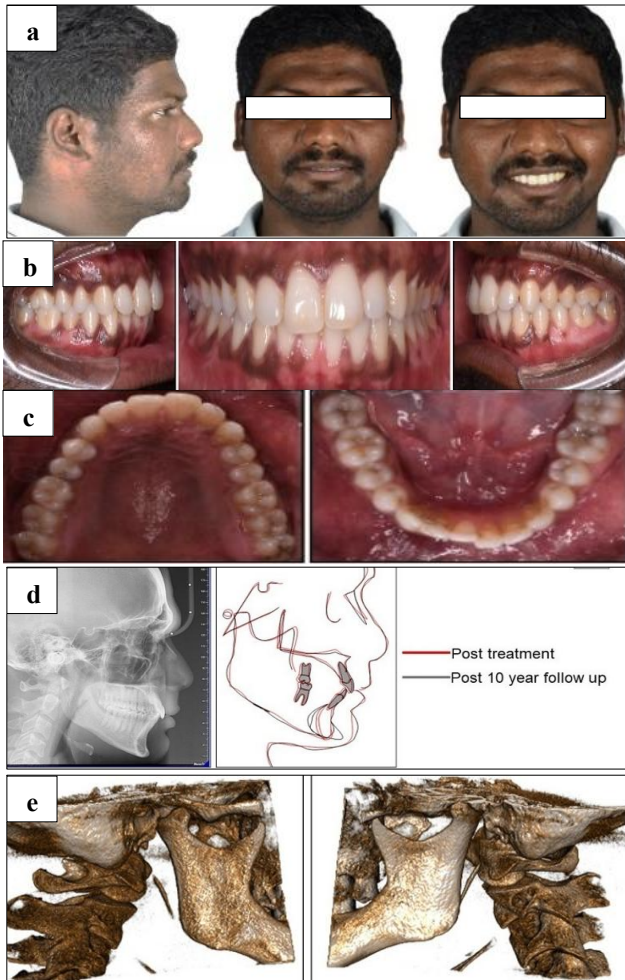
(a-e): Long-term follow-up at 10 years post-treatment showing extraoral and intraoral clinical photographs, lateral cephalometric superimposition highlighting skeletal stability, and cone-beam computed tomography (CBCT)-derived coronal sections of the right and left temporomandibular joint (TMJ) condyles.
